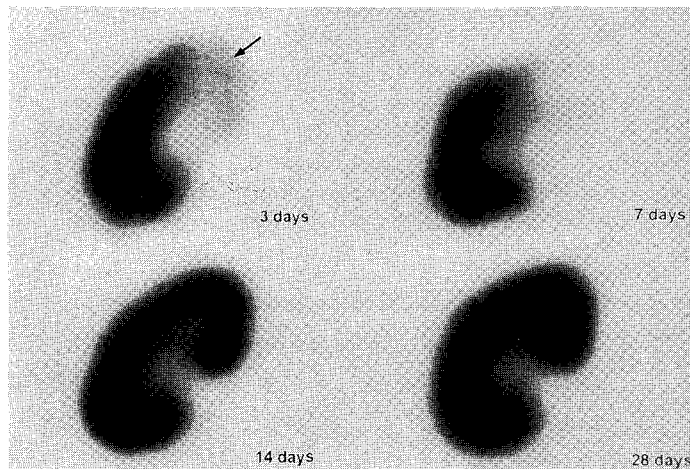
Coronal tomographs of sequential Tc-99m MAG3 renal SPECT studies in a 35 years old woman with acute tubular necrosis of the allograft kidney. There is focally decreased radioactivity (arrow) in the upper pole on the initial and first follow-up scans (3 and 7 days), which were completely resolved in further follow-up scans.
